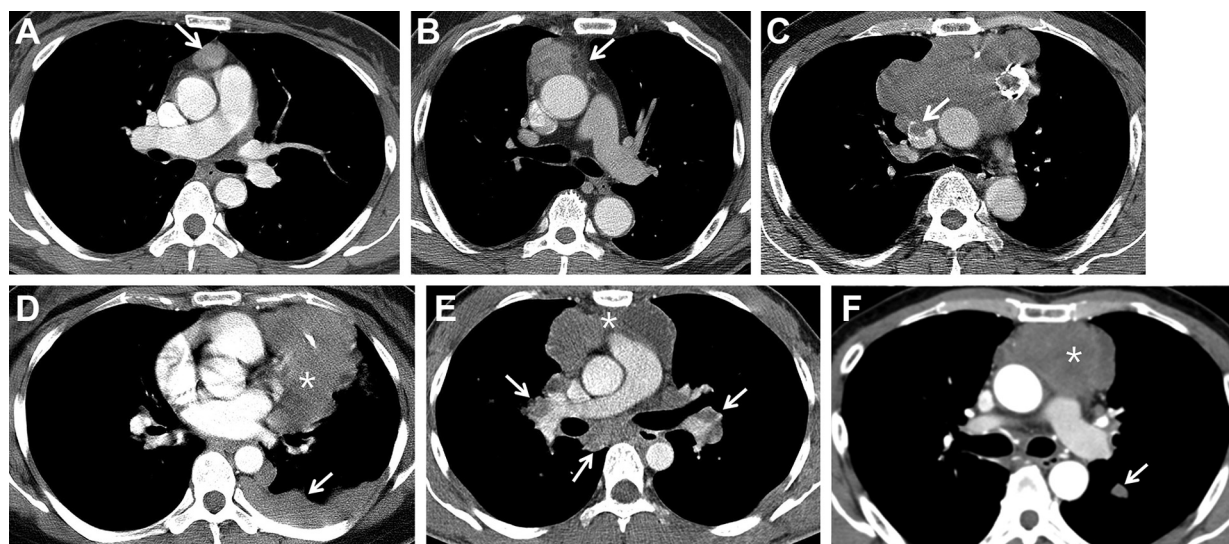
Various computed tomography (CT) stages of thymic epithelial tumors. (A) Stage I, well encapsulated thymic epithelial tumor (arrow) of World Health Organization (WHO) classification A and Masaoka-Koga stage I in a 37-year-old woman. (B) Stage II, tumor invasion into surrounding mediastinal fat (arrow) of WHO classification AB and Masaoka-Koga stage II in a 66-year-old man. (C) Stage III, tumor invasion into superior vena cava (arrow) of WHO classification B3 and Masaoka-Koga stage III in a 60-year-old man. (D) Stage IV, tumor pleural seeding (arrow) of thymic carcinoma (star) and Masaoka-Koga stage IV in a 34-year-old woman. (E) Stage IV, bilateral hilar and subcarinal lymph node metastases (arrows) of thymic carcinoma (star) and Masaoka-Koga stage IV in a 30-year-old man. (F) Stage IV, pulmonary metastases (arrow) of thymic carcinoma (star) and Masaoka-Koga stage IV in a 49-year-old man.
